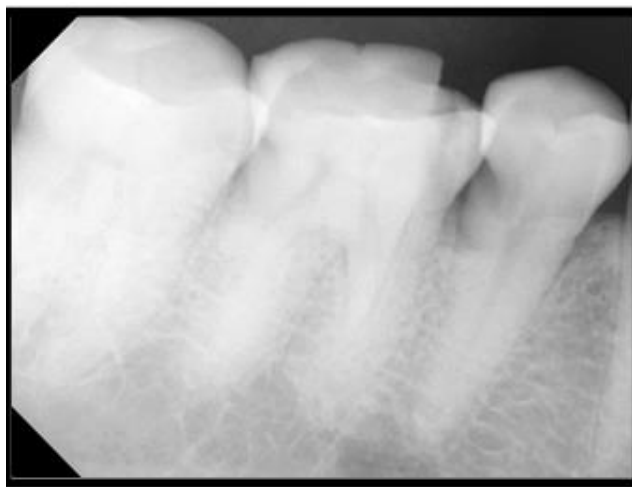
Pre-operative radiograph of #46
